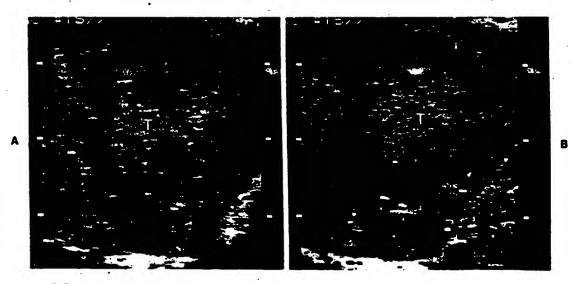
Peripheral vascular enhancement of a woodchuck hepatoma using Albunex. A, Transverse image through the hepatoma shows the ill-defined tumor to be of mildly increased echogenicity (arrows) relative to the adjacent normal parenchyma. Minimal color Doppler signal from the peripheral vessels is noted. B, After the intravenous injection of 0.2 ml/kg f Albunex, dramatic color Doppler enhancement of the peripheral vessels of the tumor occurs. (From Goldberg BD, Hilpert PL, Burns PN et al, with permission.)
